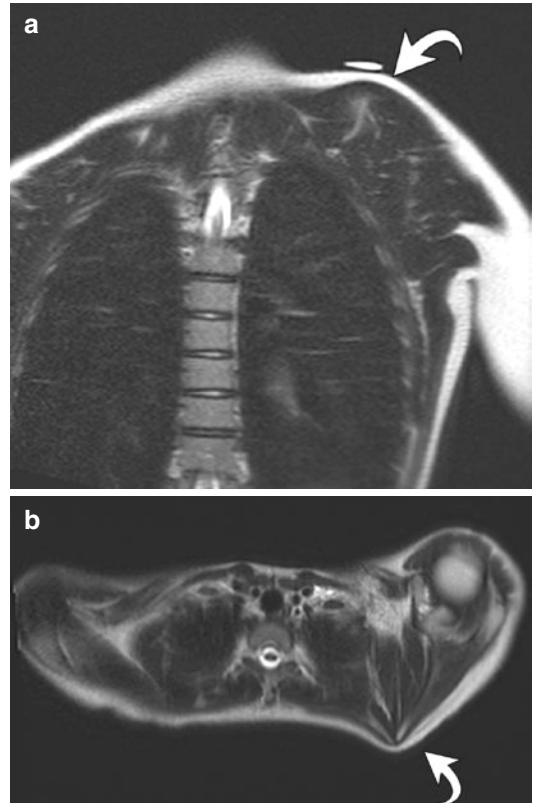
13-Year-old female with clinical evidence of left scapular winging after a fall. Coronal (a) and axial (b) T2-weighted images show left scapular winging (curved arrow) characterized by deformity and scapular malalignment without muscle edema
